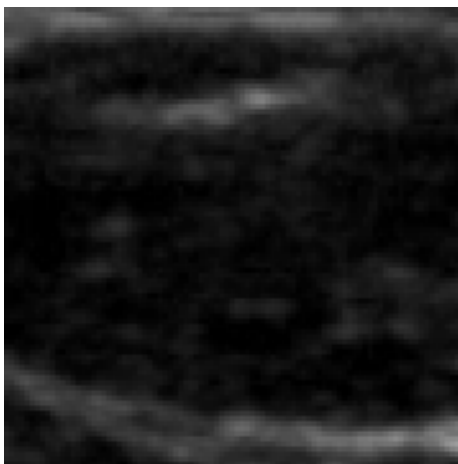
A sample ultrasound label patch where the IJV is entirely outside the patch.
